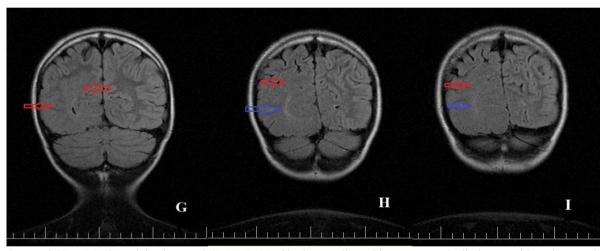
Image G,H and I. T1-weighted coronal FLAIR MRI of brain revealing white matter markedly increased in volume and isointense to cortical gray matter (red arrows) and increase signal intensity in the white matter (WM) consistent with dysmyelination (blue arrows).
